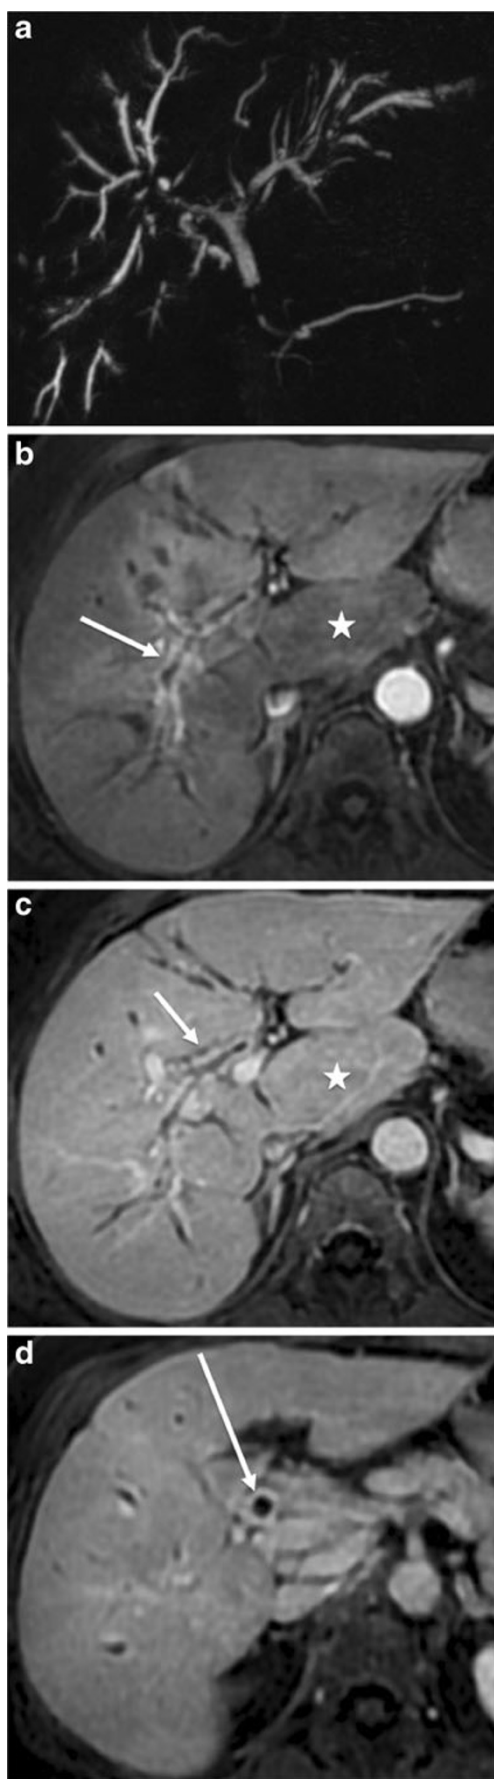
Diffuse and severe cholangitis in a 64-year-old woman. Maximum intensity projection coronal MRCP (a), T1-weighted transverse acquisitions with fat saturation after gadolinium chelate injection obtained at arterial (b), portal (c) and delayed phase (d) show biliary irregularities and stenoses (a) associated with intense biliary contrast uptake of the thickened biliary walls at the arterial (*white arrows* in b) and portal phase (*white arrow* in c). The common bile duct presents with the same abnormalities (*white arrow* in d). Note the segment I hypertrophy (*white star* in b and c)
